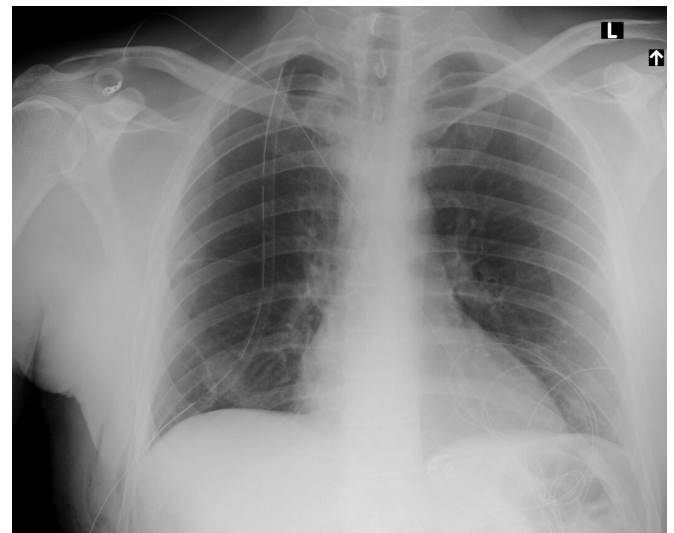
Case 10. X-ray after drain and VATS
